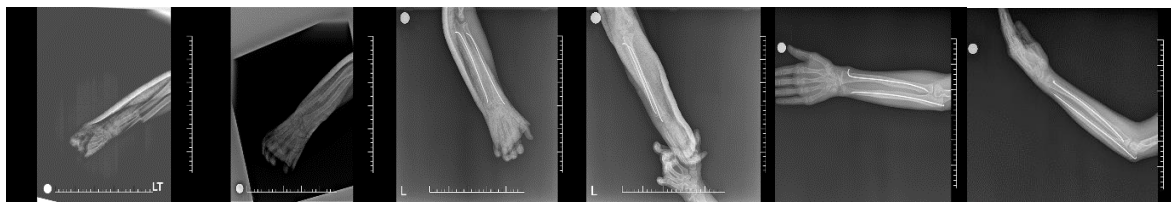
X-rays of forearm fracture with TEN applied, A) preoperative B) postoperative and C) final polyclinic control
